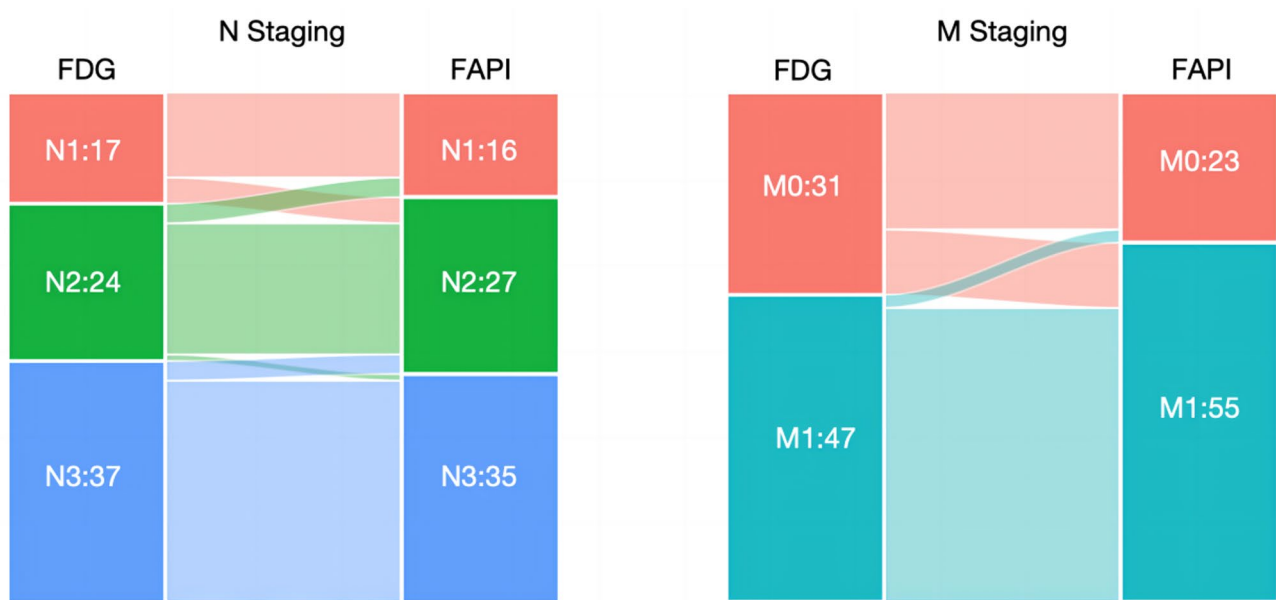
Sankey plots displaying [^{99m}Tc]Tc-FAPI SPECT/CT and [¹⁸F]FDG PET/CT related changes in N and M staging of gastrointestinal cancer.
